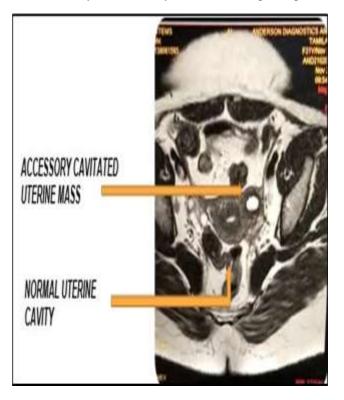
Pre-operative image-MRI pelvis.
